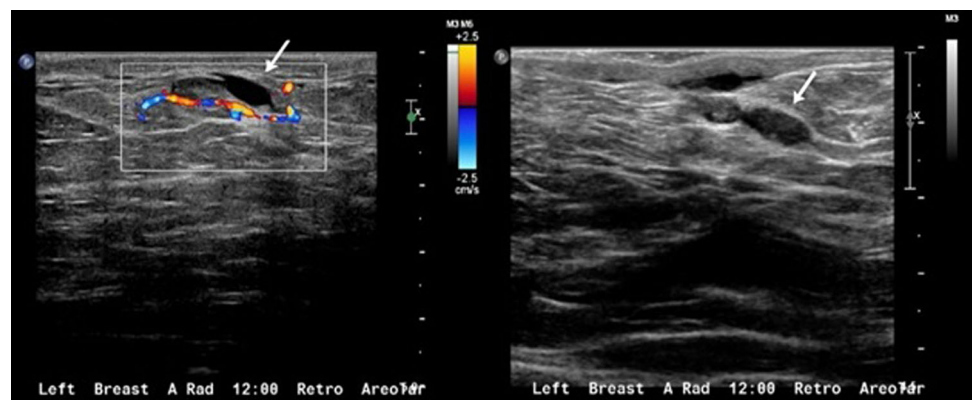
Grayscale and color Doppler ultrasound images of the left breast demonstrate duct ectasia with an intraluminal mass (arrow) which was sampled with a 14-gauge core biopsy needle under ultrasound guidance, yielding intraductal papilloma
